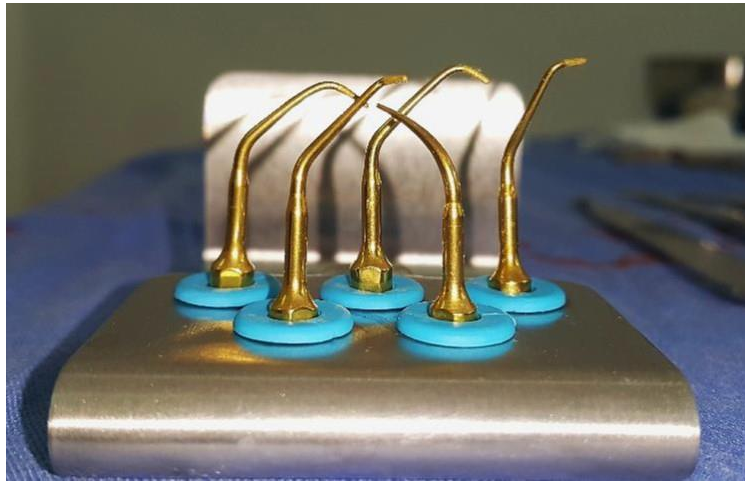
Mectron ultrasonic retro-preparation tips kit.
